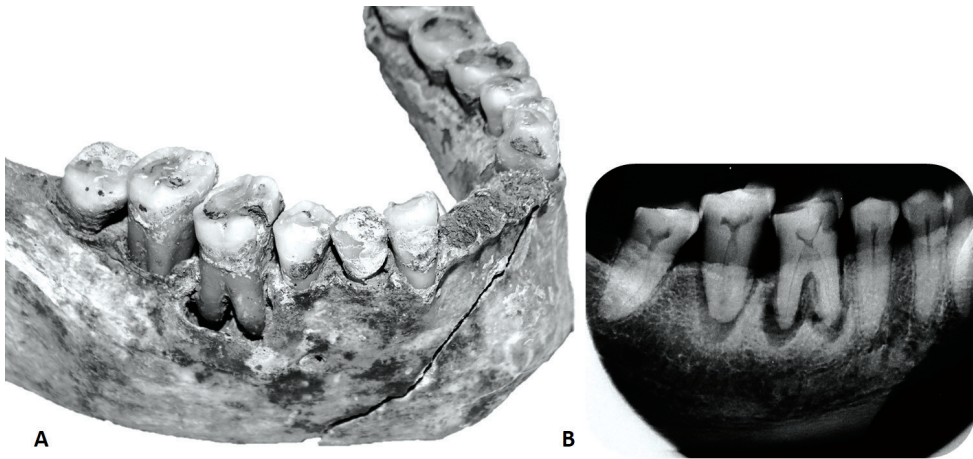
40-45 year-old female, buried around 250 AD. Pulpal exposure as a result of deep caries. Note resultant extensive bone loss and full exposure of both mesial and distal roots (A). Large apical bony defects on both mesial and distal roots and furcation involvement were verified on X-ray image (B).
